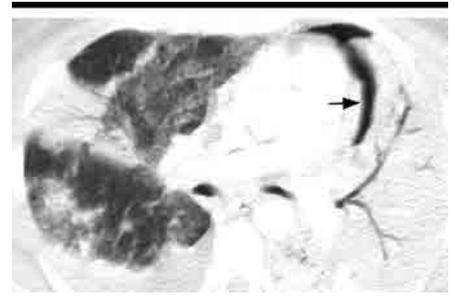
Acute respiratory distress syndrome secondary to trauma in a 50-year-old woman. Transverse CT image shows patchy geographic lung consolidation on the right with more diffuse consolidation in the left upper lung. A small left pneumothorax (arrow) is present.
